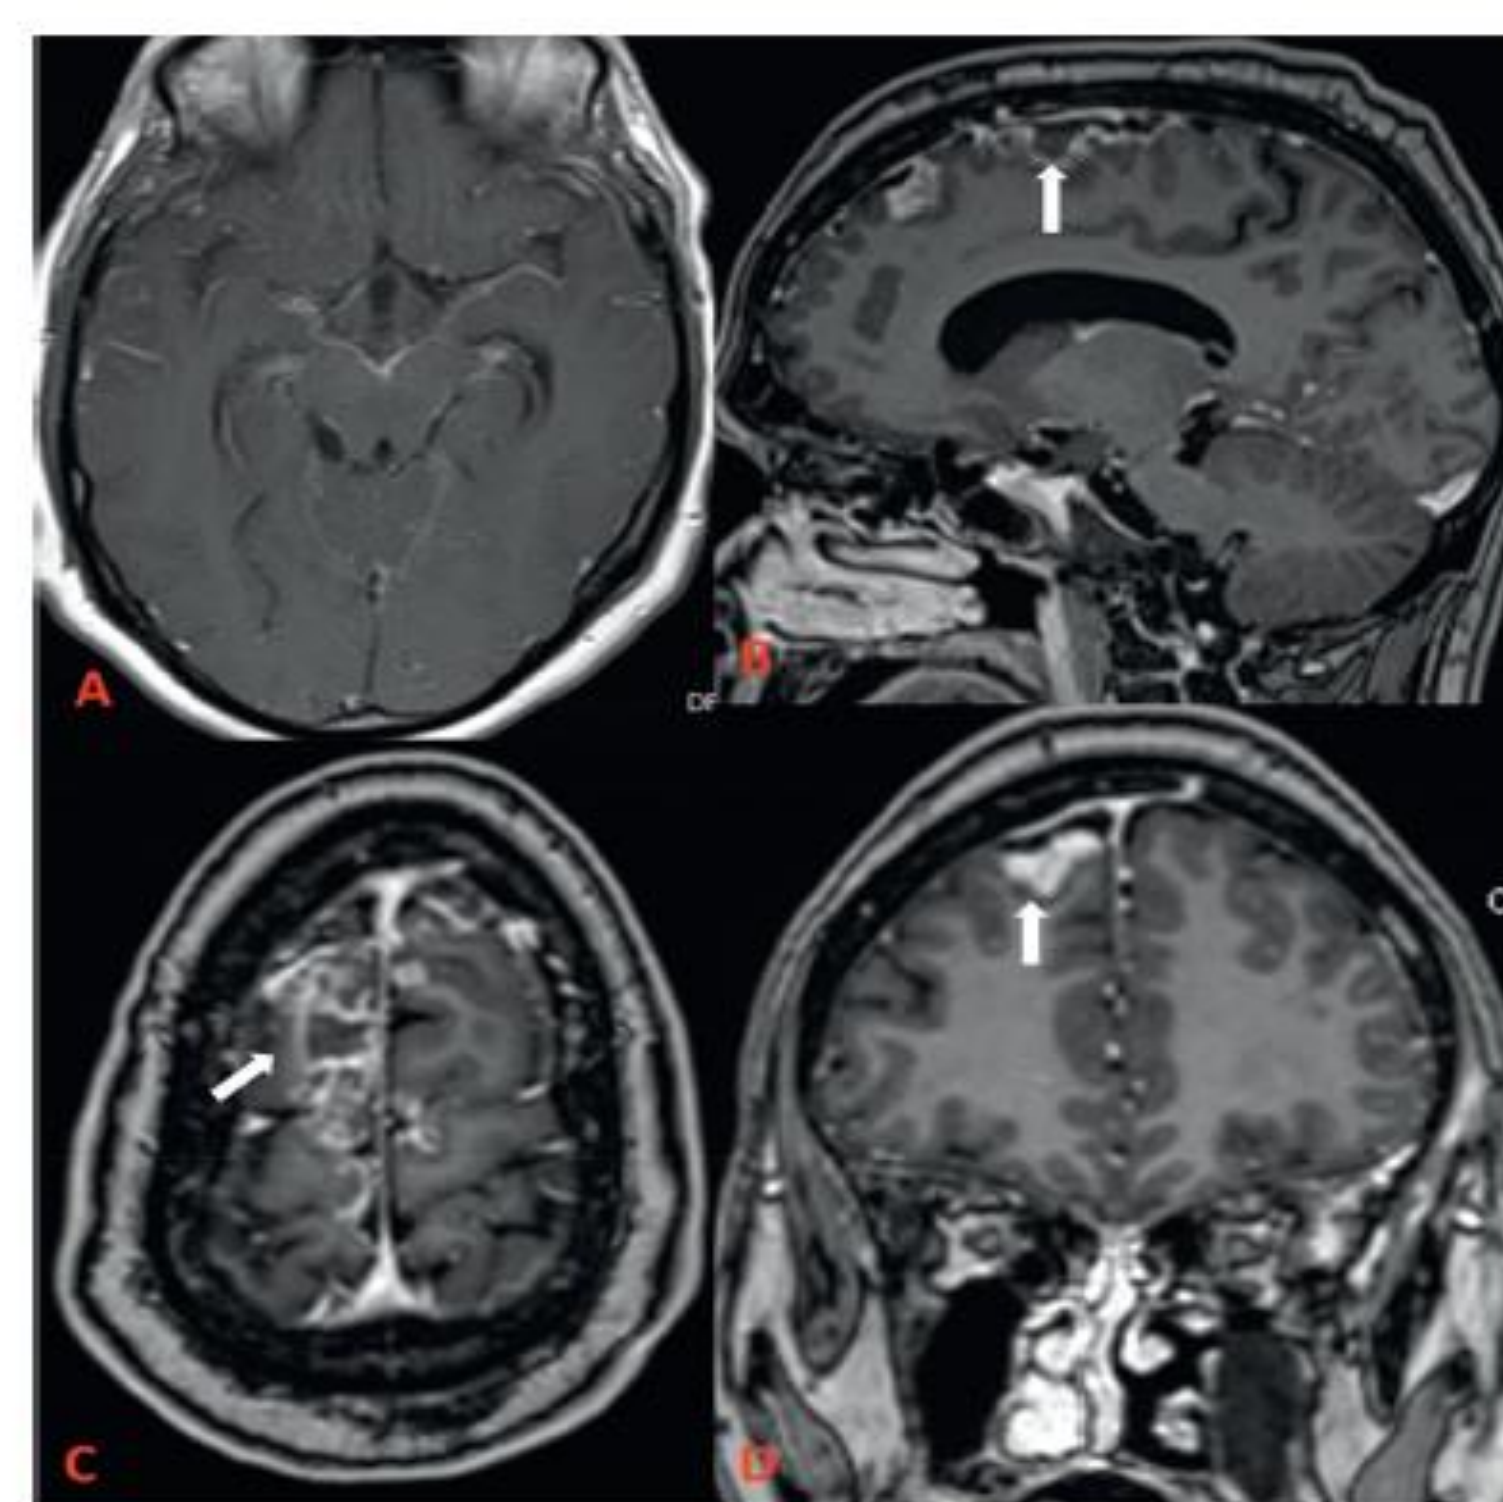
MRI brain examination of a 48-year-old male with meningoencephalitis, vasculitis, and extradural fluid collection. Postcontrast MRI axial T1 (A), GRE sagittal (B), GRE axial (C), and GRE coronal (D) images show diffuse leptomeningeal enhancement, enhancing basal exudates and high biparietal epidural fluid collection (white arrow) with cerebritis.
